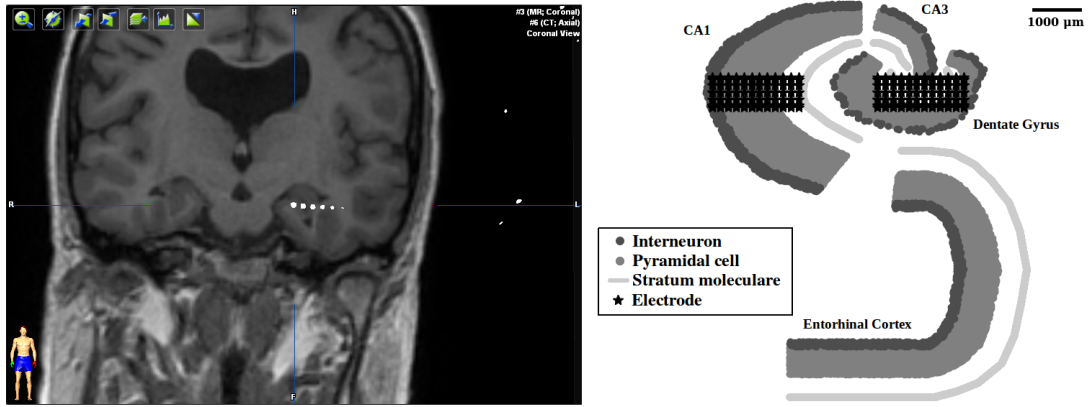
Left - Coregistered CT-MRI image of the implantation of an S EEG electrode in the patient's hippocampus (coronal view). Right - Topology of the modeled hippocampal network.
